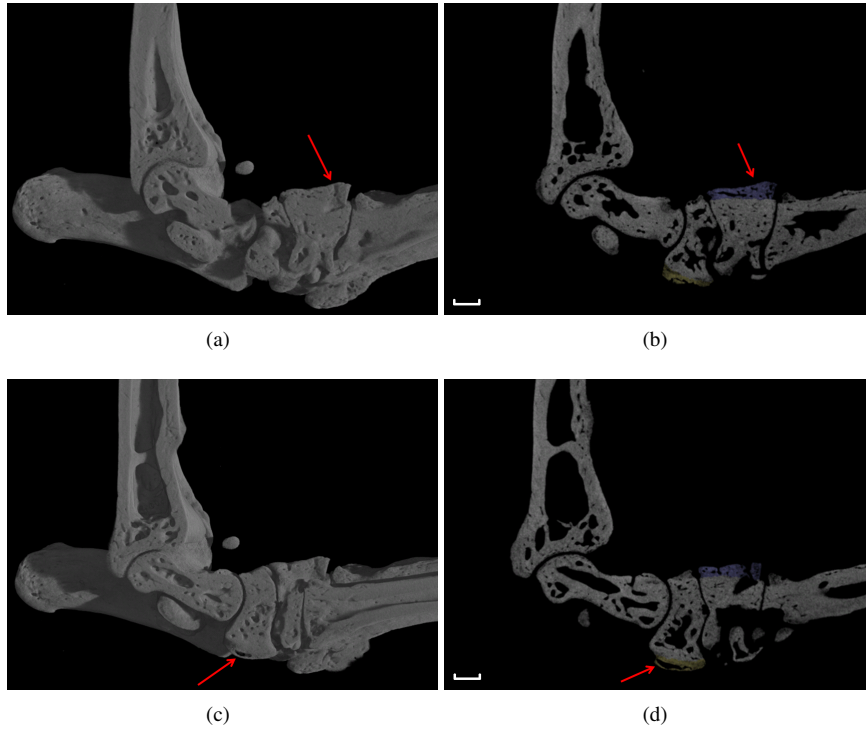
Osteophyte at the dorsal surface of the lateral cuneiform: (a) sagittal section through a 3D rendering and (b) sagittal CT image with the selected ROI in purple; Osteophyte at the plantar surface of the navicular bone: (c) sagittal section through a 3D rendering and (d) sagittal CT image with the selected ROI in yellow. Scale bar = 0.5 mm.
